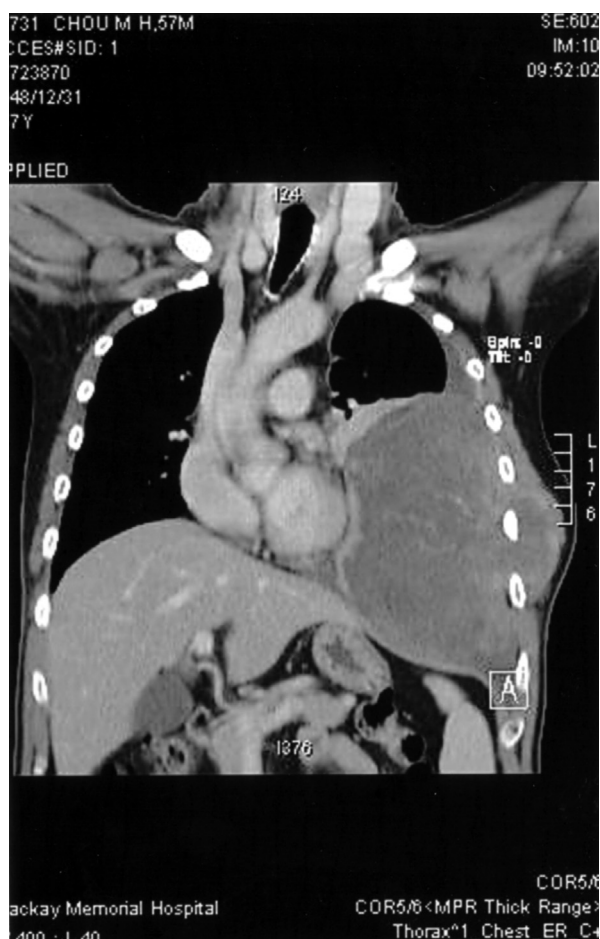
Chest CT scan with enhancement revealing a massive left pleural effusion with adjacent atelectatic lung and soft tissue thickening of the left lateral chest wall
